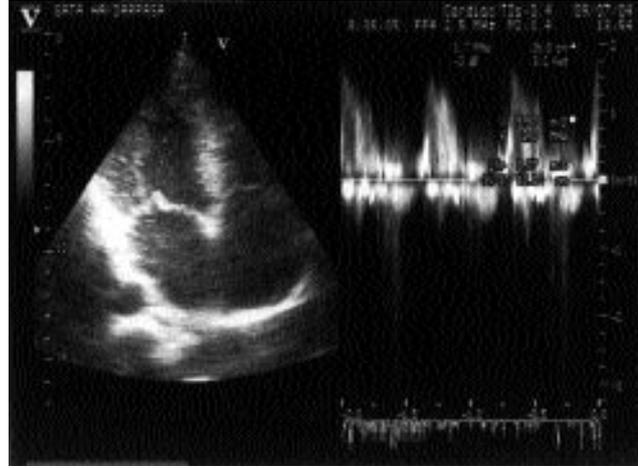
Echocardiographic image five years after surgery.
